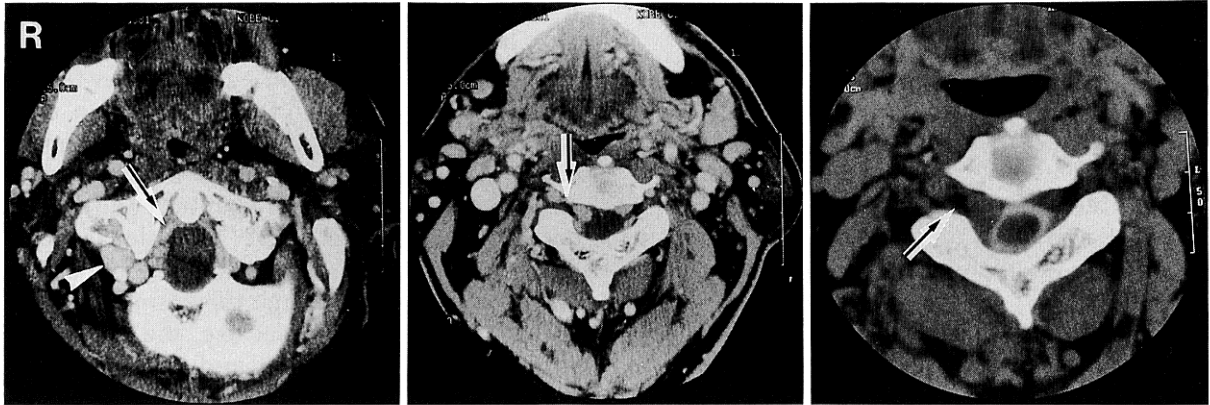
left and center*: Computed tomography (CT) scans with contrast media showing the fistula (arrowhead) above the arch of C-1 with the greatly enlarged epidural venous plexus (arrow). *right*: CT myelogram showing compression of the spinal cord and subarachnoid space by an epidural mass (arrow).
